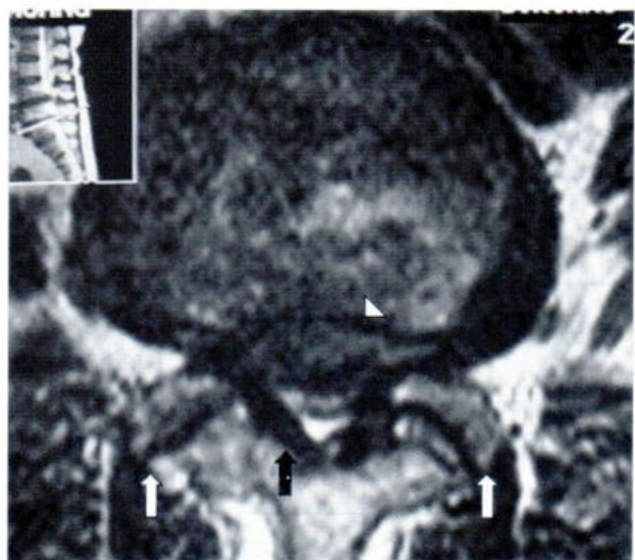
Axial T2-weighted SE MR image of the lumbar spine in a 68 year-old woman with low back pain, radicular pain relieved by squatting showed severe central canal stenosis due to facet joint hypertrophy (white arrow), ligamentum flavum hypertrophy (black arrow) and herniated disk (white arrow head).
